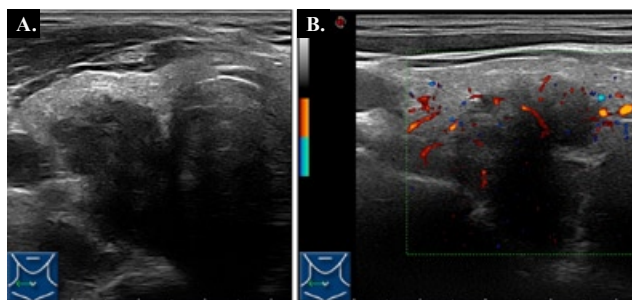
Thyroid ultrasonography showed a lobulated, solid, noncalcified, hypoechoic nodule (A) with moderate vascularity on color flow image (B).
